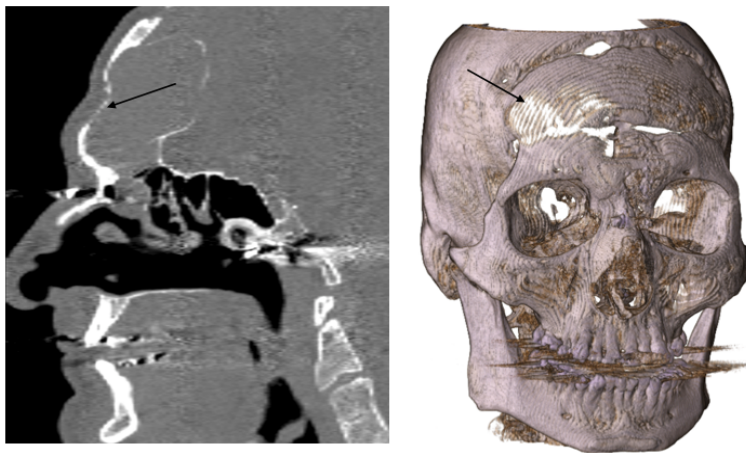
Frontal bone erosion in patient 6: Sagittal view of representative slice and 3D bone window of pre-operative CT
